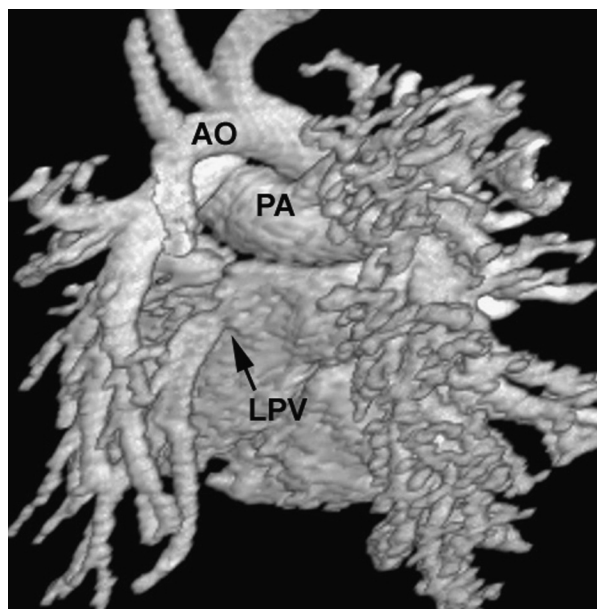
FIGURE e62-11 Three-dimensional MRI demonstrating stenosis of the left lower lobe pulmonary vein. AO = aorta; LPV = left pulmonary vein; PA = pulmonary artery.
